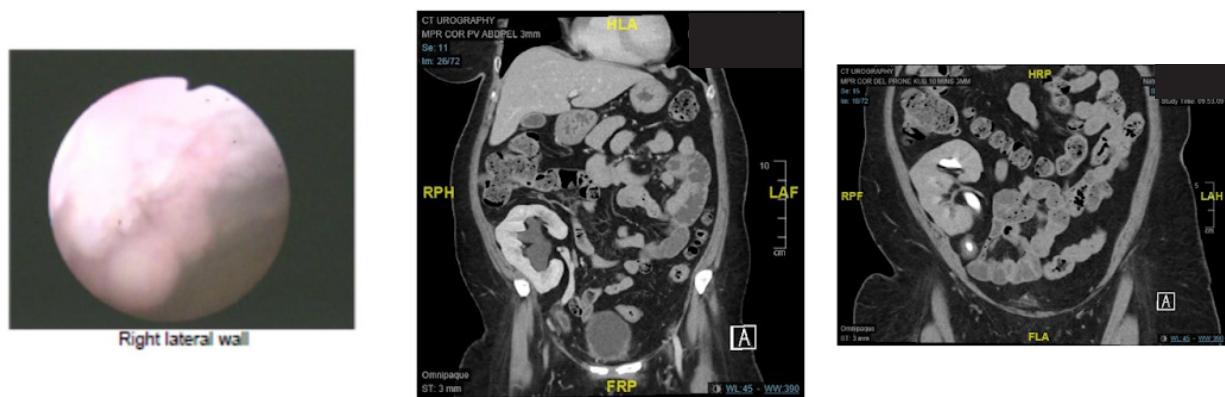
Bladder cancer on cystoscopy at transplant ureter-bladder anastomosis (left); CT scans (April 2018) depicting a hydronephrotic transplant kidney with dilated ureter to level proximal to anastomosis, where tumour was found (right).
